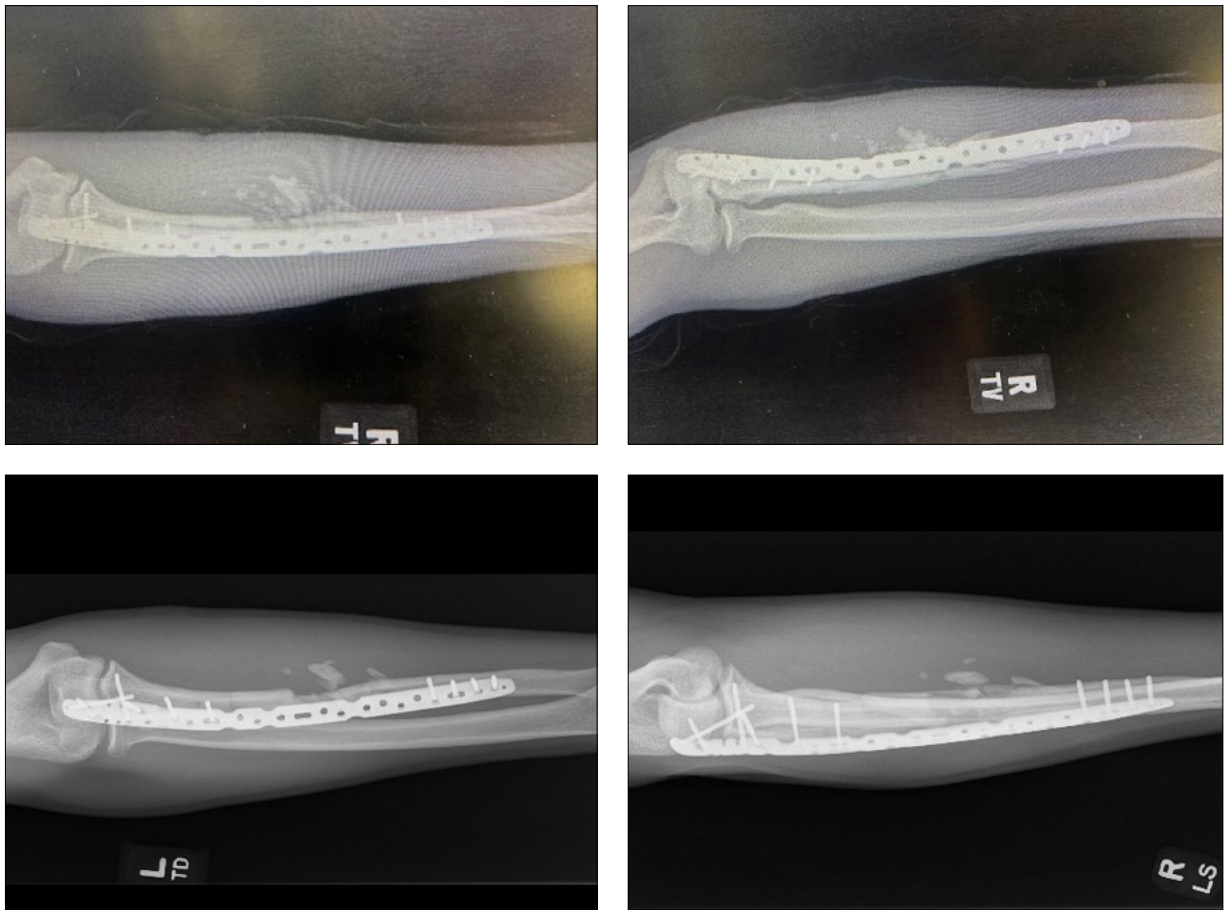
Postoperative X-ray images after 2 weeks (top row) and 12 weeks (bottom row).
